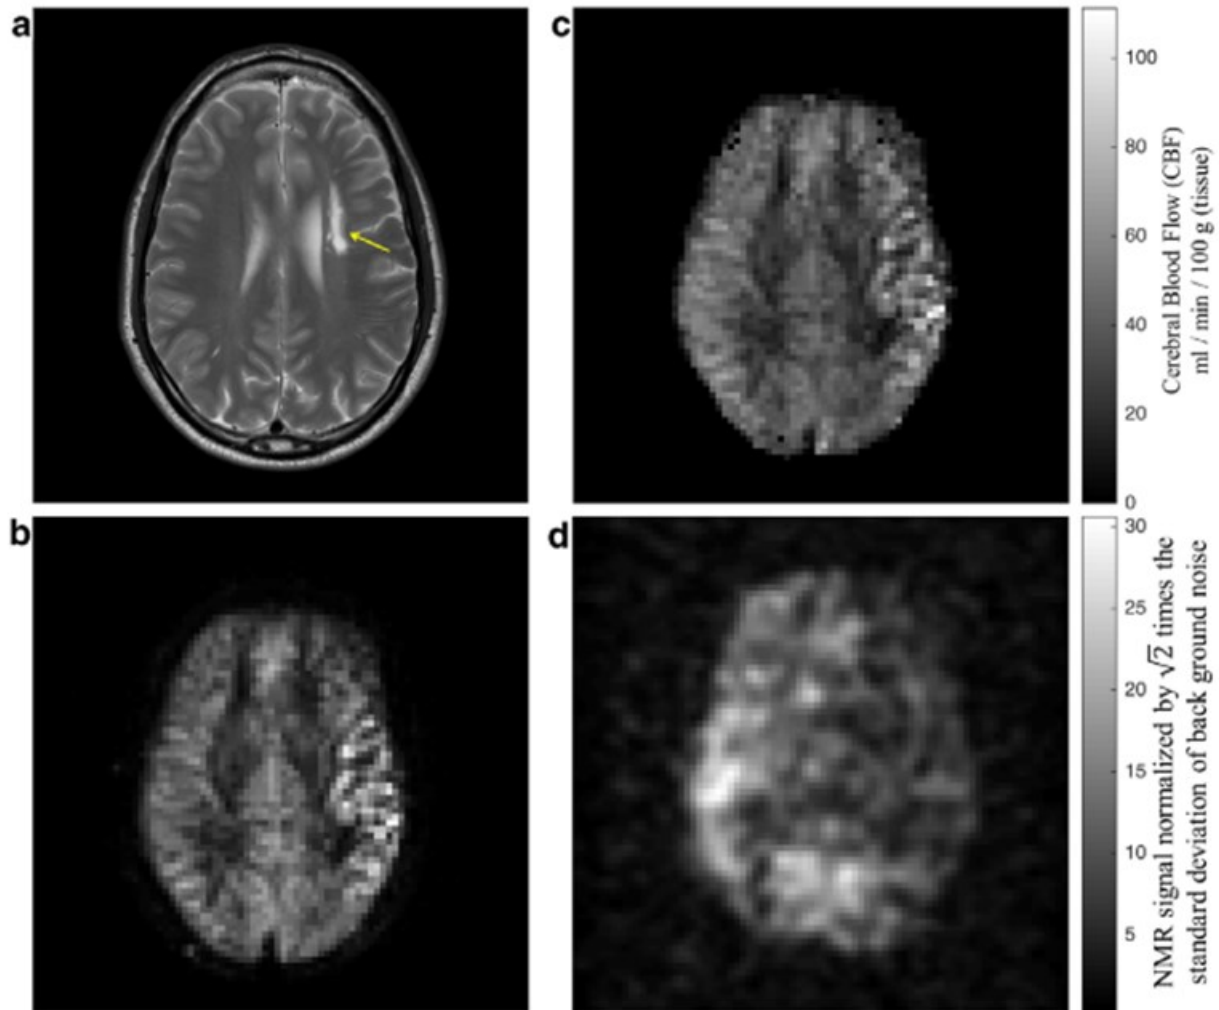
Brain MR images acquired in the same session from a subject with established stroke. (a) axial T₁-weighted image showing infarct in the centrum semiovale of the left cerebral hemisphere (arrow). (b) An axial image from pseudocontinuous ASL shows hyperintensity in the cerebral cortex adjacent to infarction. (c) Map of CBF estimated from ASL in (b) shows increased perfusion. (d) Hyperpolarized ¹²⁹Xe brain image shows reduced uptake in the brain tissue supplied by the left internal carotid artery. The ¹²⁹Xe signal in the region of hypointensity in (d) was 60% lower when compared with the average signal in the healthy region. Images are reprinted with permission from the publisher⁷⁴.
